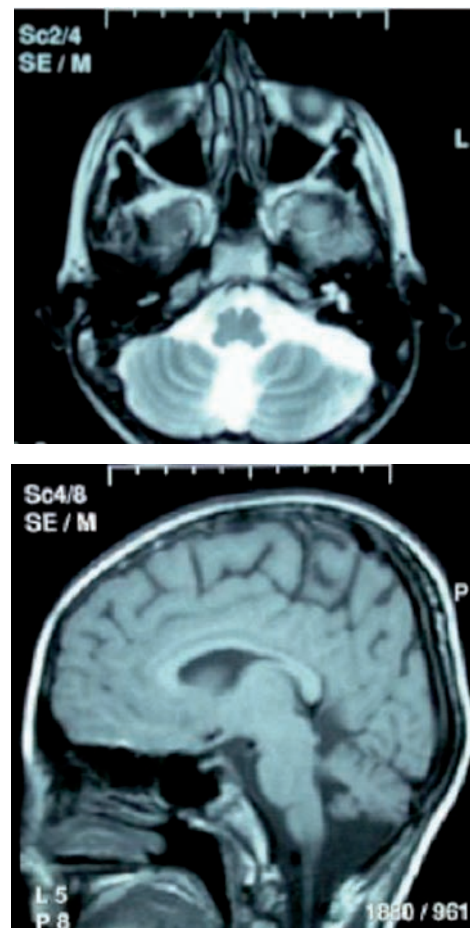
Magnetic resonance image of the patient's brain at the age of 11 years, demonstrating cerebellum (a). Cerebellar vermis hypoplasia (b).
